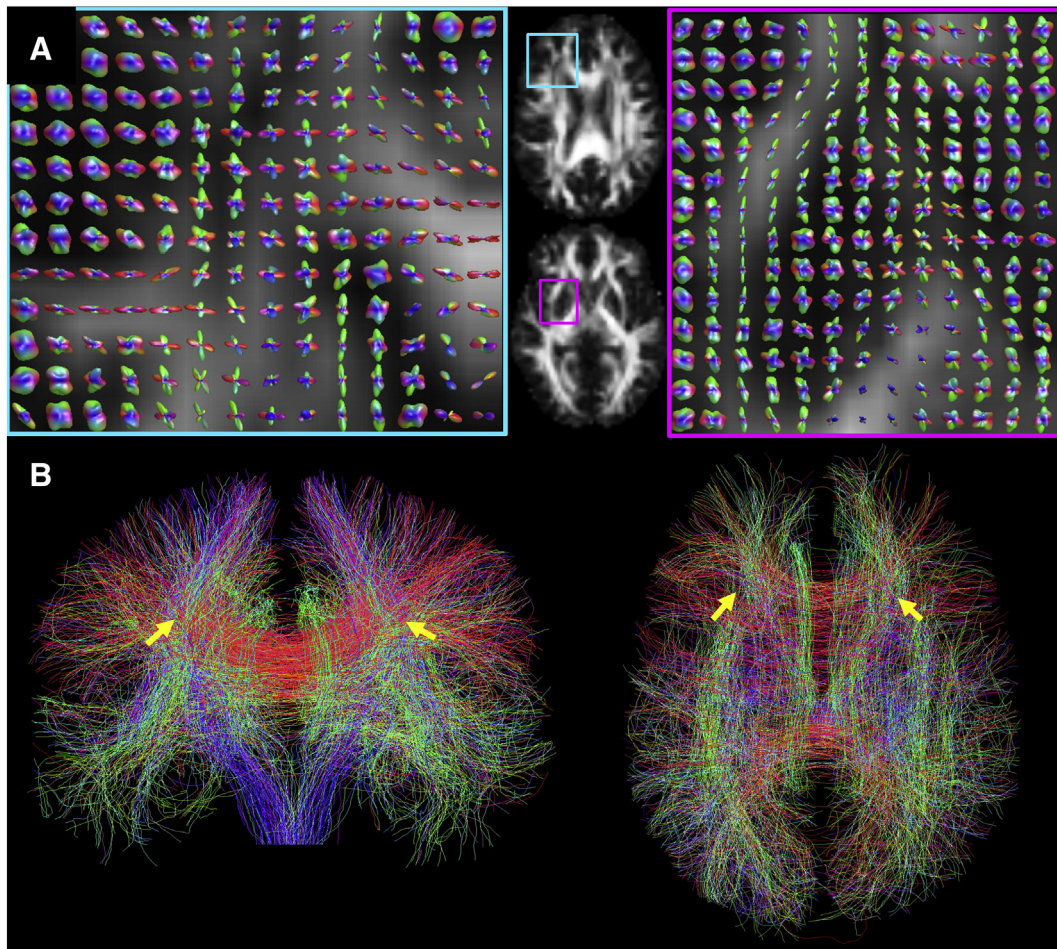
Glyph representation of propagator ODFs reconstructed using MAP MRI in two regions of complex tissue microstructure (A). Whole-brain tractography using ODFs derived from MAP MRI can be used to resolve crossing WM fiber pathways (B).
